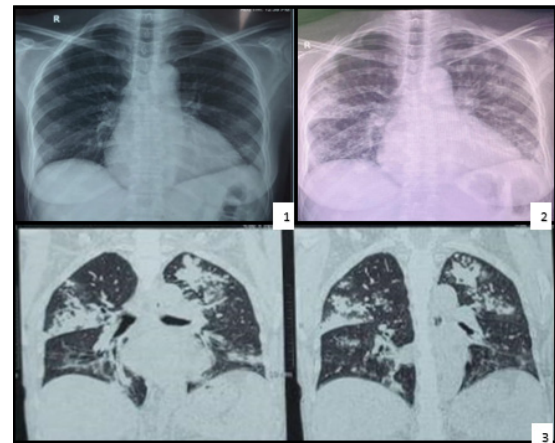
(1) Chest radiography of patient at presentation was normal. (2) Chest radiography of patient after 2 days of receiving steroids shows bilateral infiltrates. (3) Computed tomography chest showing multifocal patches of consolidation with no zonal or lobar predominance.
